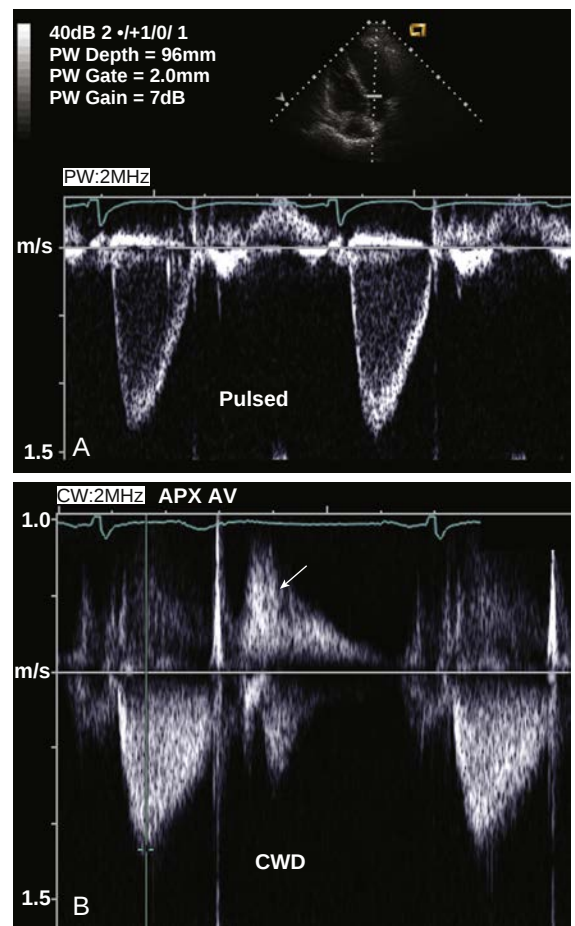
LV outflow. (A) LV outflow is recorded with the Doppler sample volume on the LV side of the aortic valve either in an anteriorly angulated 4-chamber view or in an apical long-axis view. The normal smooth “envelope” of flow with dense signals along the outer edge and few velocity signals within the curve are seen. Again, the baseline and scale are adjusted to prevent aliasing and allow accurate measurements. (B) Aortic flow velocity is recorded from an apical approach using CW Doppler (CWD). This velocity tracing includes signals from the entire length of the ultrasound beam so that the velocity curve is filled in by lower velocities proximal to the valve. The aortic closing click is seen. In diastole, the relatively broad CW beam intersects the LV inflow curve (arrow).
